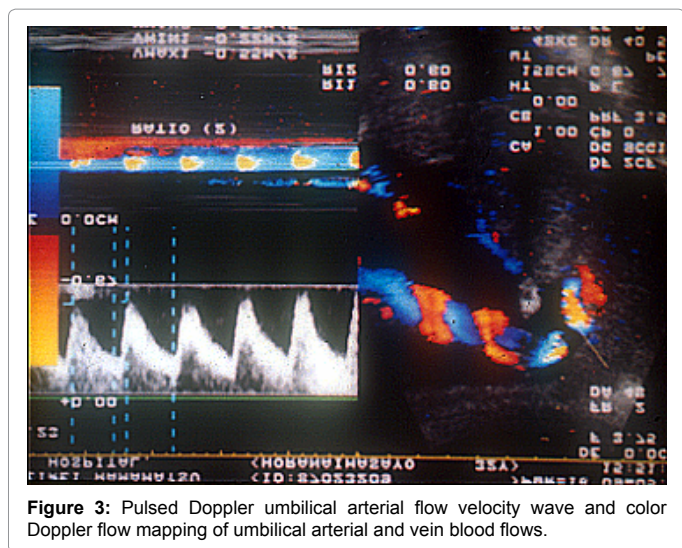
Pulsed Doppler umbilical arterial flow velocity wave and color Doppler flow mapping of umbilical arterial and vein blood flows.
